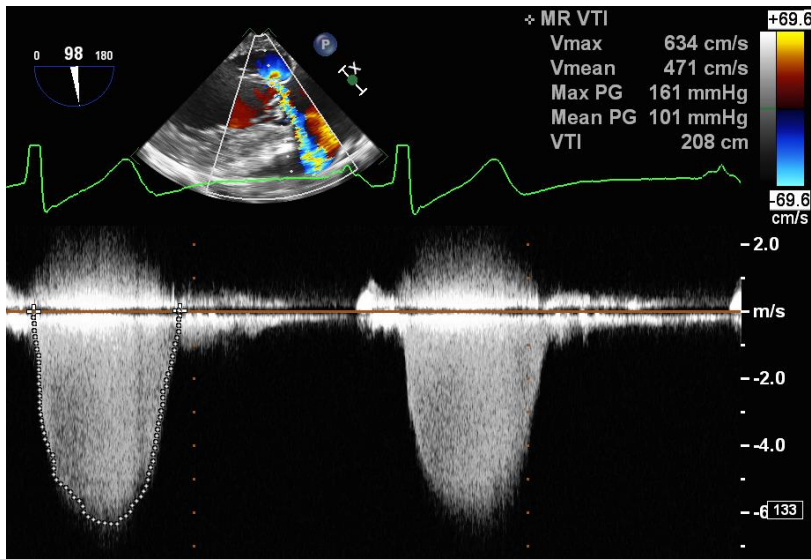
Severe mitral regurgitation. Continuous wave spectral Doppler tracing of the mitral regurgitant jet. Optimal alignment of the regurgitant jet was obtained from the transgastric long axis view (98°). The peak velocity is 634cm/s with velocity time integral (VTI) measurement 208cm. The effective regurgitant orifice area (EROA) calculation based on Figure 18 is  $(2\pi r^2 \times \text{aliasing velocity})/\text{peak regurgitant velocity}$ , or  $0.4\text{cm}^2$  consistent with severe mitral regurgitation. The EROA multiplied by the MR VTI provides a regurgitant volume of 84mL.
